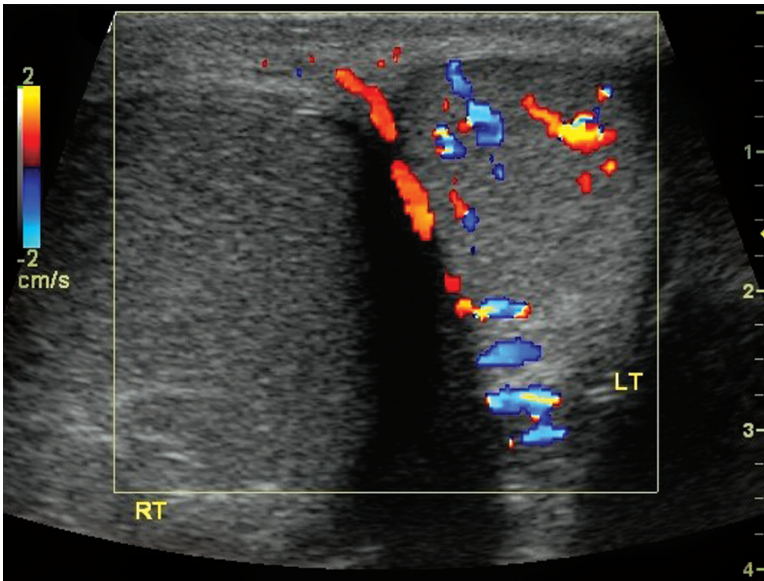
Ultrasound with Doppler flow showing testicular torsion
